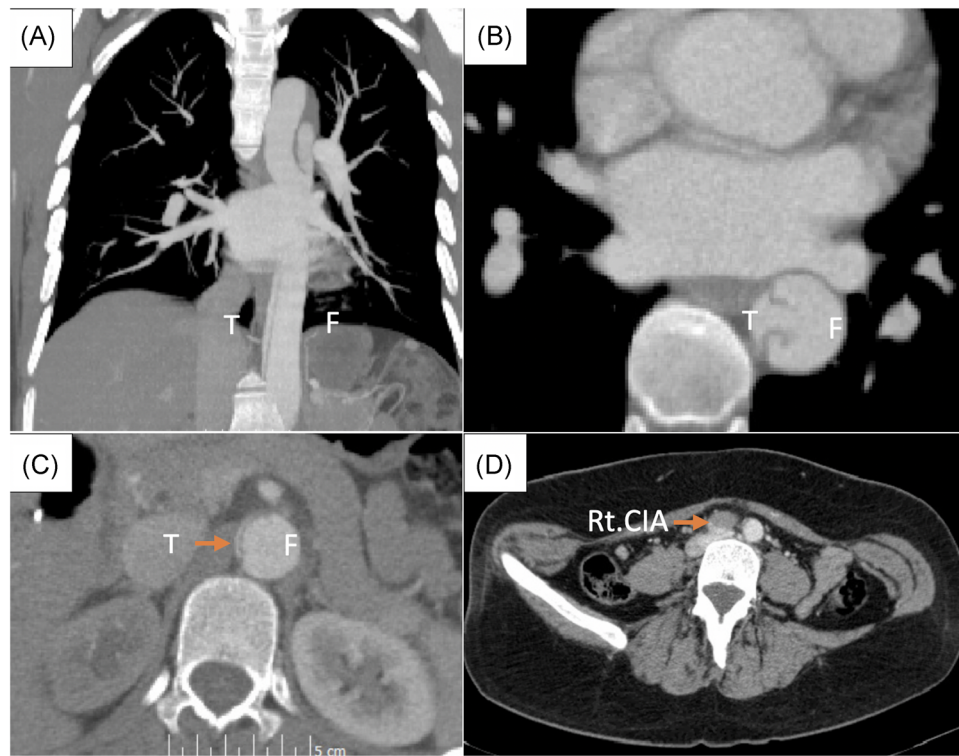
Preoperative computed tomography scan which shows: A, Dissection started at the proximal descending aorta. The TL was significantly compressed by the FL. B, The entry tear was seen in the mid-descending aorta. C, Right kidney flow was diminished as the TL is significantly compressed. D, A flow of the Rt. CIA decreased. FL, false lumen; Rt. CIA, right common iliac artery; TL, true lumen
